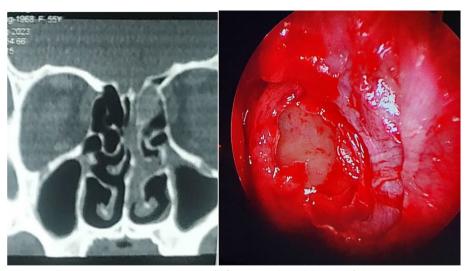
Preoperative CT scan and intraoperative endoscopic picture of left anterior ethmoidal sinus. Left showing pre-operative CT scan with left anterior ethmoid sinus mucosal thickenings, on right side showing intraoperative endoscopic picture of the same patient after 5 weeks. Anterior ethmoids were clear intraoperatively
